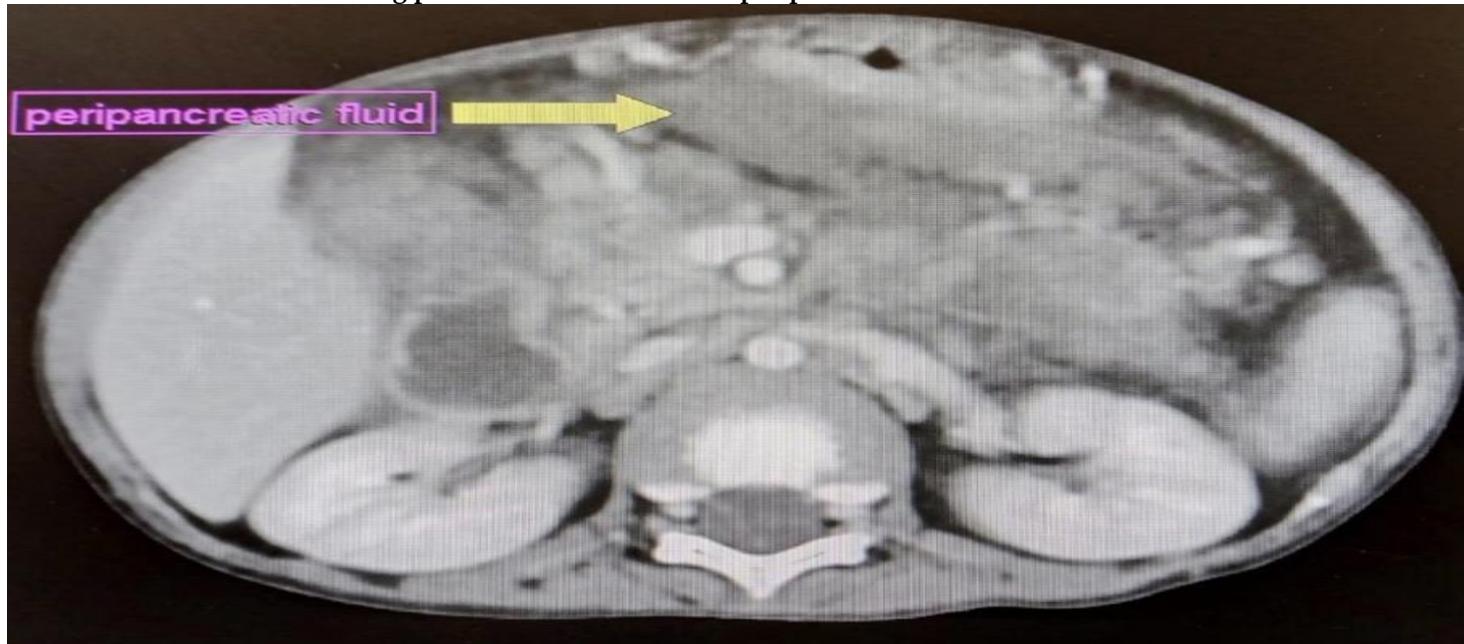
CT scan showing well-defined intra- and peripancreatic fluid collections consistent with pseudocysts, representing sequelae of prior inflammatory episodes in chronic pancreatitis
